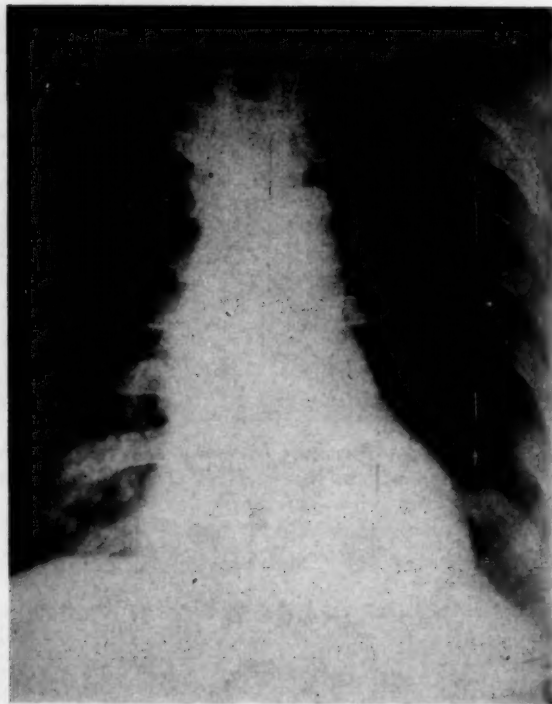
Initial x-ray film of chest taken on Feb. 24, 1955, showing multiple metastases in both lungs.
